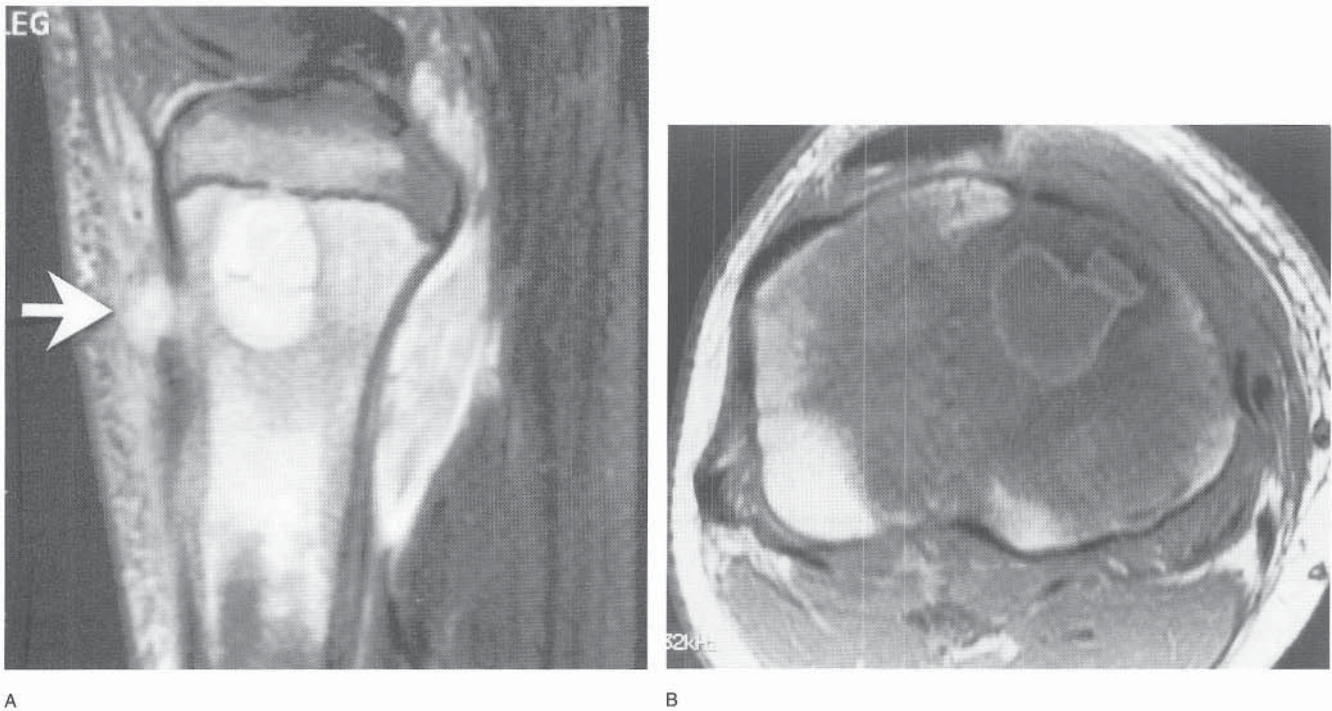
MR image demonstrating intraosseous abscess. A, Sagittal image of a metaphyseal lesion abutting the physis. There is also extrusion into the anterior pretibial soft tissues (*arrow*). B, Axial view demonstrating gadolinium enhancement surrounding the rim of the lesion. The abscess is nonenhancing.
